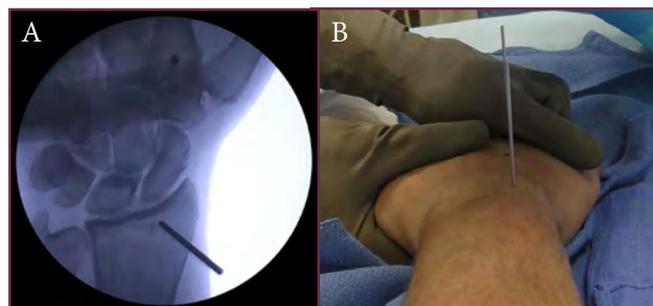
(A) Radiograph of the hand, showing wire placement in the distal radius. (B) Coronal view along the long axis of the forearm, showing the K-wires placed in the distal radius and second metacarpal. Notably, the wires are placed parallel to one another; thus, the second metacarpal wire is blocked from view by the distal radius wire.
